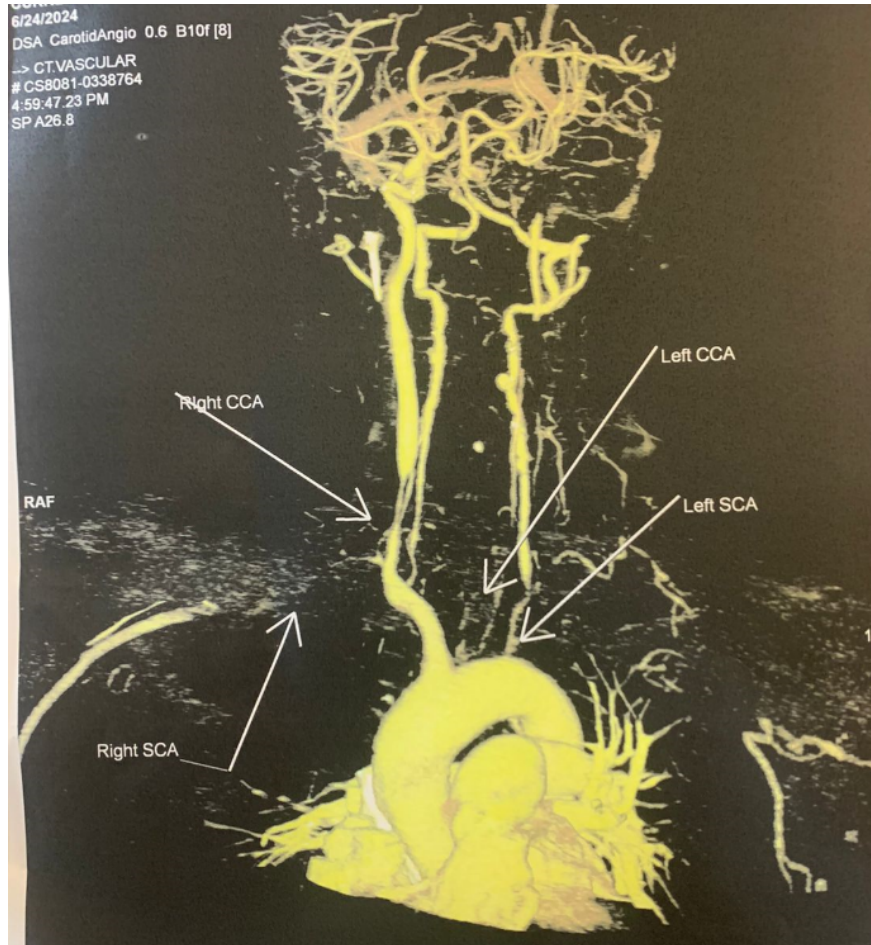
Carotid CT angiogram.
